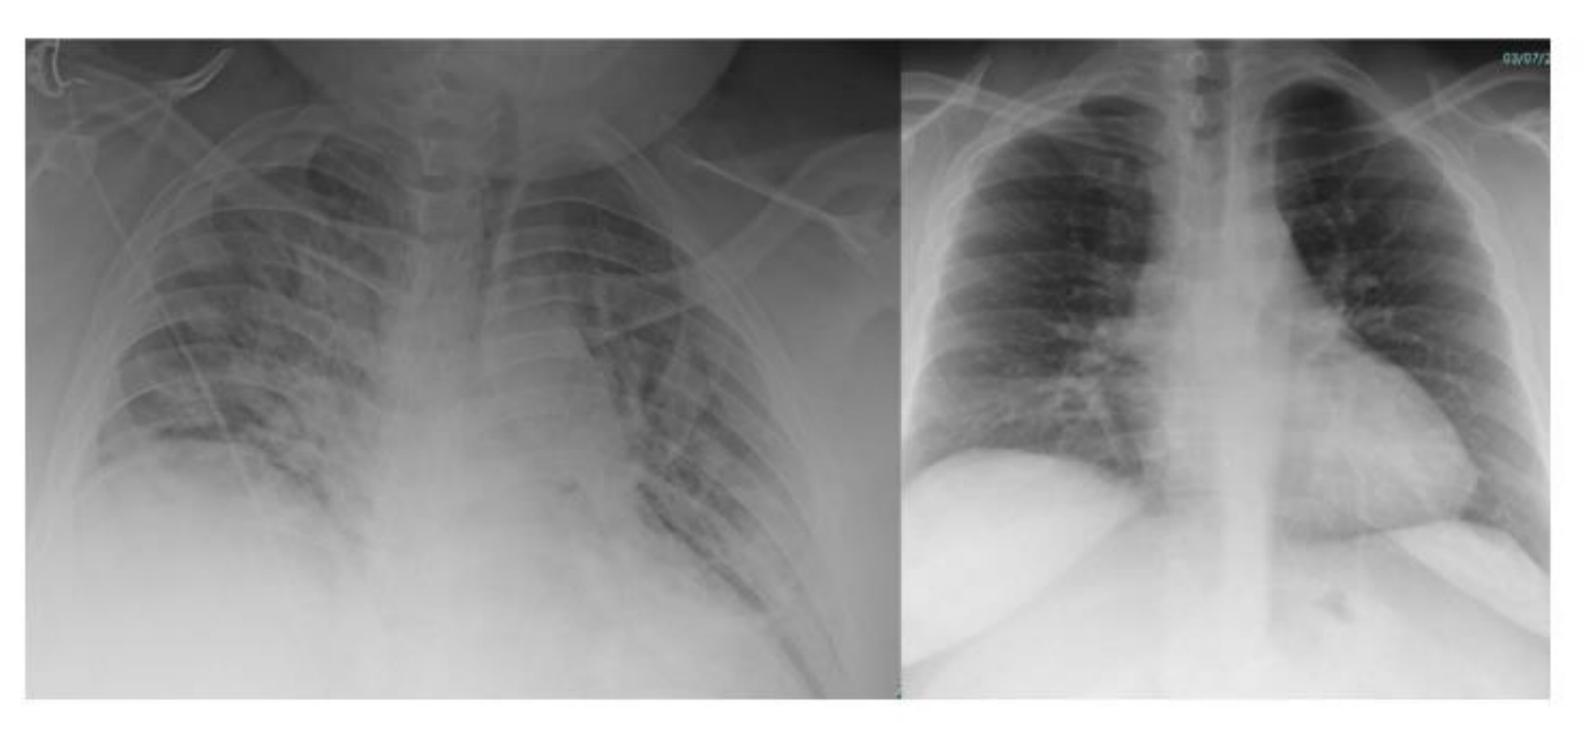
Chest X-ray on day 1 (left) and after discharge (right)
